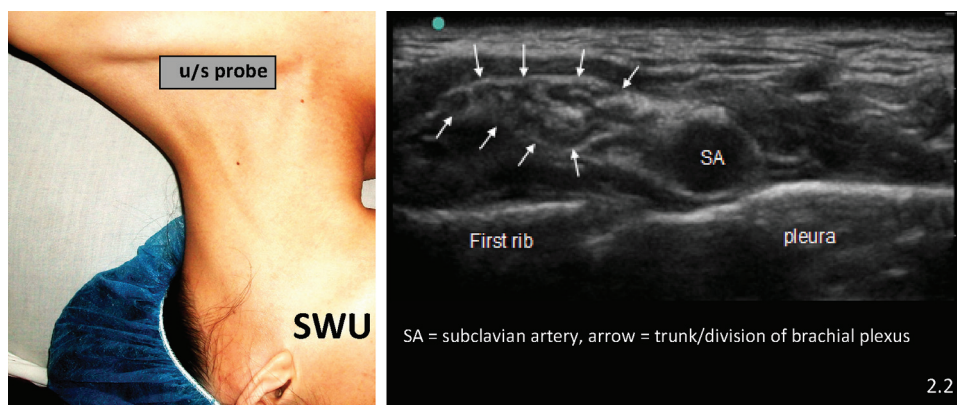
Sonographic image of anatomy from placing the linear probe on supraclavicular area.
